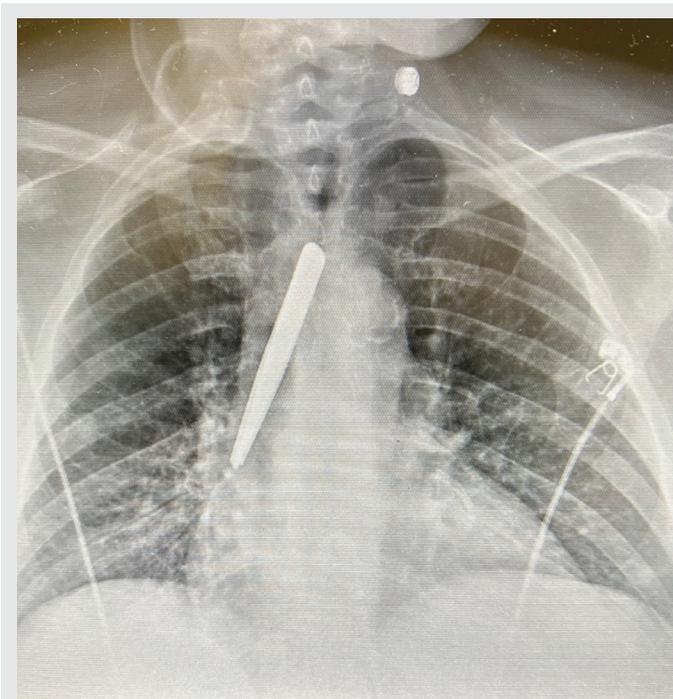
Chest x-ray reveals a tweezer in the right mainstem bronchus and mid trachea.
